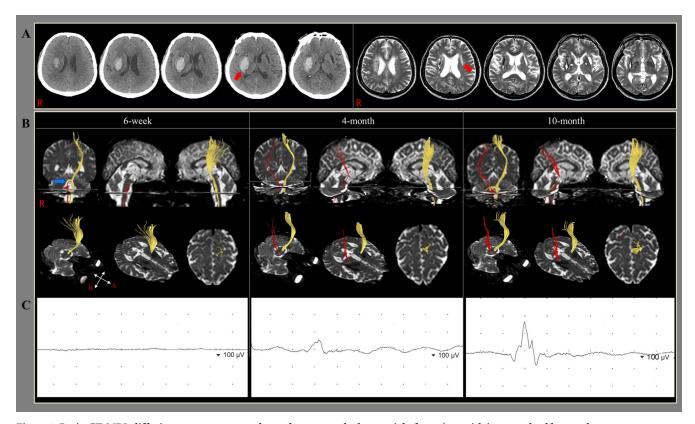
Brain CT, MRI, diffusion tensor tractography, and motor-evoked potential of a patient with intracerebral hemorrhage. (A) Brain CT, taken at onset of intracerebral hemorrhage, shows a hematoma (arrow) in the right putamen and brain MRI at 6 weeks after onset shows a leukomalactic lesion (arrow) at the left corona radiata and basal ganglia due to a previous undiagnosed putaminal intracerebral hemorrhage. (B) Results of diffusion tensor tractography (DTT). The right corticospinal tract (CST) showed discontinuation (arrow) in the brainstem on 6-week DTT images. However, this discontinued right CST was elongated to the right primary motor cortex on 4-month DTT and had become thicker on 10-month DTT. (C) Motor-evoked potentials (MEPs) obtained from the left abductor pollicis brevis muscle. No MEP was evoked from the right hemisphere, even though stimulation intensity was increased to 100% of maximal output at 6 weeks. However, transcranial magnetic stimulation at 4 and 10 months showed that MEPs were evoked from the right hemisphere (4 months: latency 25.4 ms and amplitude 100  $\mu$ V; 10 months: latency 22.9 ms and amplitude 270  $\mu$ V).
